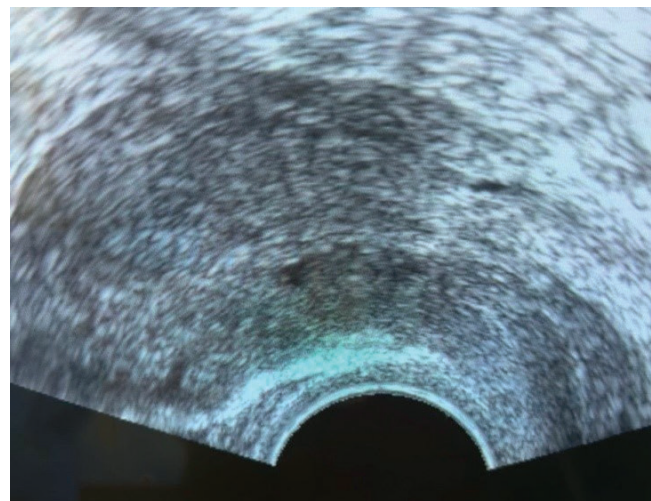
Transvaginal grayscale ultrasound image of the uterus at 2 weeks post UAE with subsequent uterine aspiration
